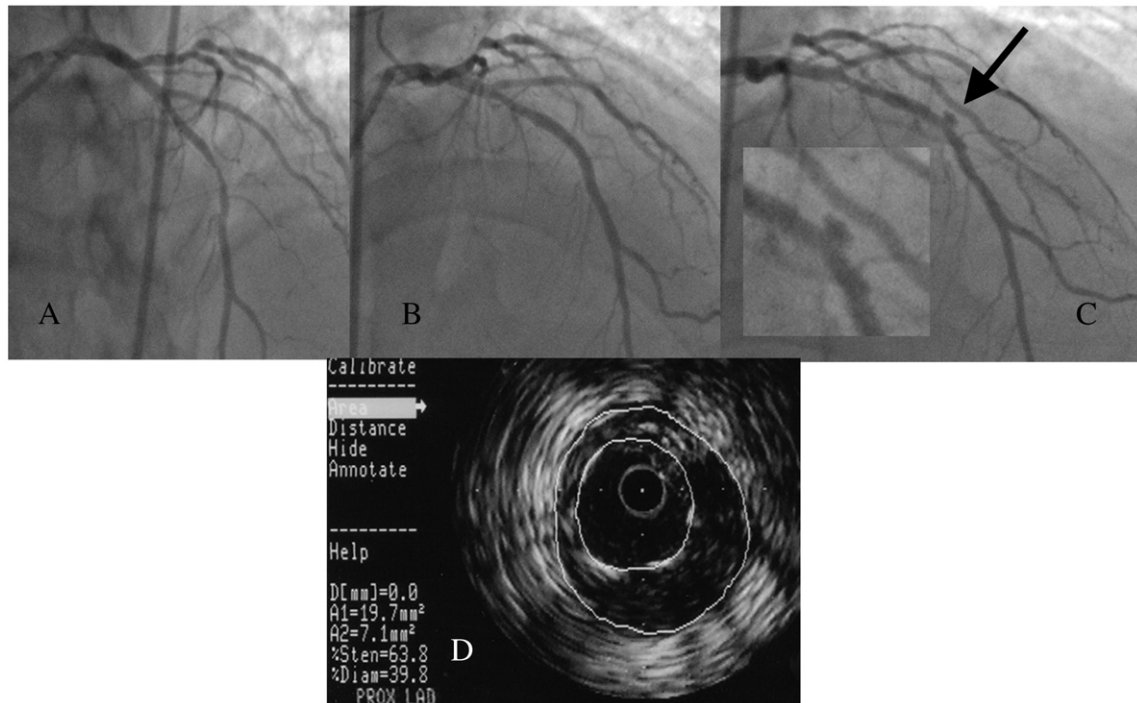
Coronary angiography of the left anterior descending artery (A) — mid-vessel stenosis prior to intervention, (B) — mid-vessel following stenting, showing no residual stenosis, aneurysm or angiographic dissection, (C) — aneurysm formation within the stented segment (arrow), and (D) — intravascular ultrasound showing an aneurysm within the stented segment in the mid-left anterior descending artery. Cross-sectional area of aneurysm 19.7 mm², cross-sectional area of stented segment lumen 7.1 mm².
